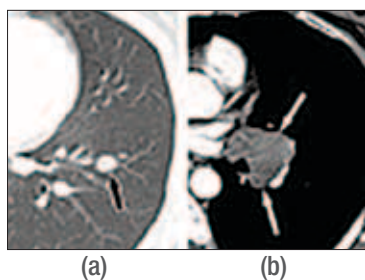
Bronchial NET in a 42-year-old woman. (a) Axial CT scan (5.0-mm section thickness) obtained at the level of the basal segmental bronchi shows a small (10-mm diameter), well-defined nodule (arrow) in the left lower lobe. (b) CT scan (mediastinal window) obtained at the level of the left basal trunk shows enlarged left hilar lymph nodes (arrows).
